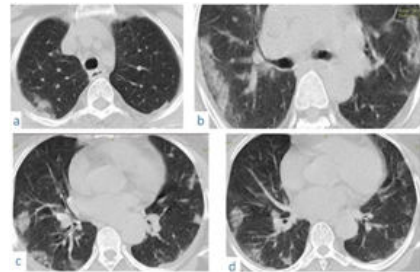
CT chest axial images (a–d) of a male patient (50 years old) with COVID-19, shows bilateral consolidation predominantly subpleural in location . (CORADS VI and CT severity score – 16/25 -mild).
